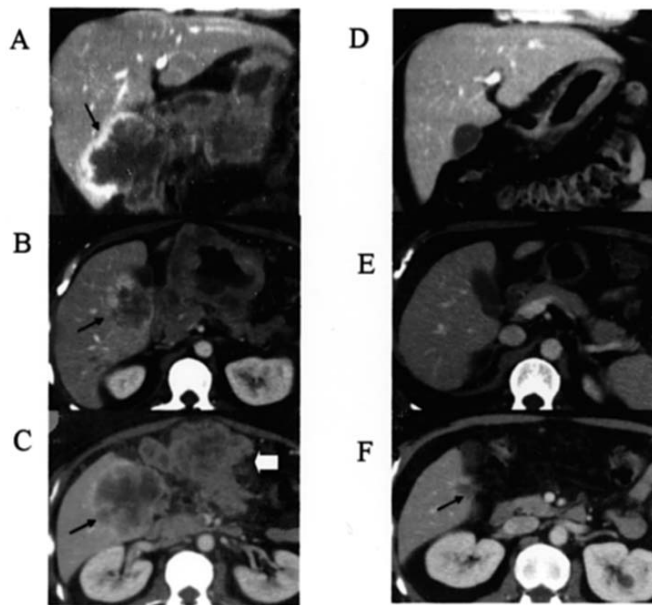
Computed tomography (CT) scans demonstrated a marked thickening of the gastric wall, bulky mass (arrow head) and metastatic liver tumor (arrow) before chemotherapy (A-C). Complete disappearance of the abdominal mass and the cystic lesion in the liver was observed after 10 cycles of chemotherapy (D-F).
